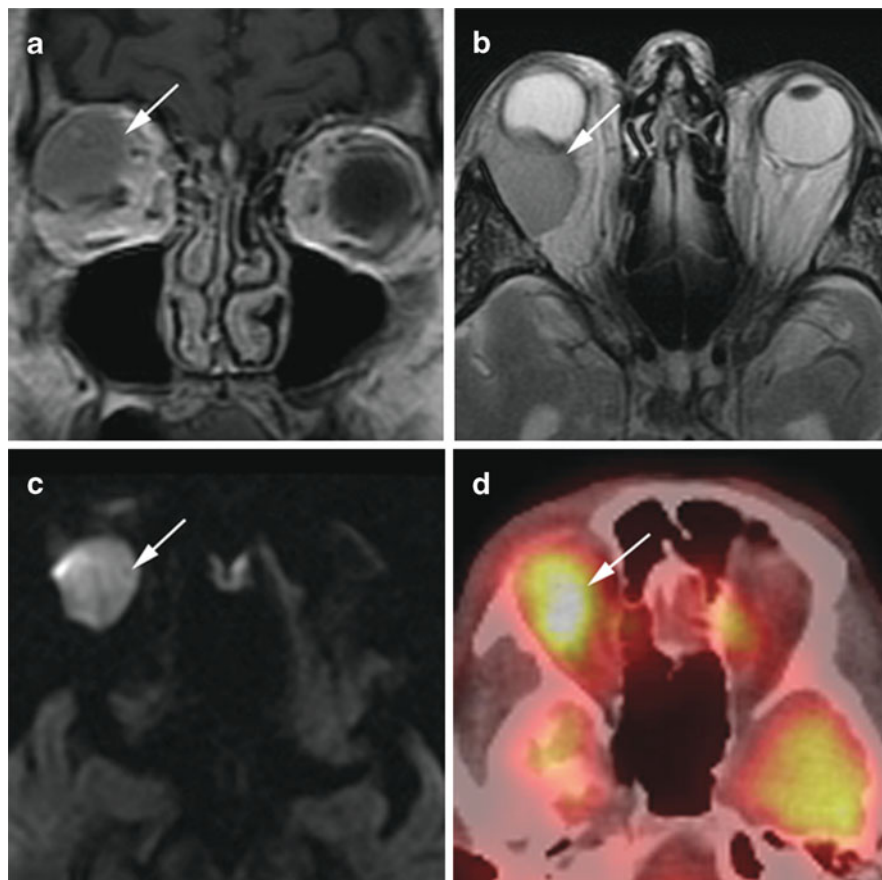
Orbital lymphoma, right orbit. (a) Coronal T1 postcontrast image demonstrates an enhancing superior right orbital mass (arrow). (b) Axial T2 image shows the mass is isointense to brain parenchyma (arrow). (c) Axial diffusion-weighted sequence shows decreased diffusion within the mass (arrow). (d) PET/CT axial plane image shows an 18F-fluorodeoxyglucose avid right orbital lesion (arrow)
